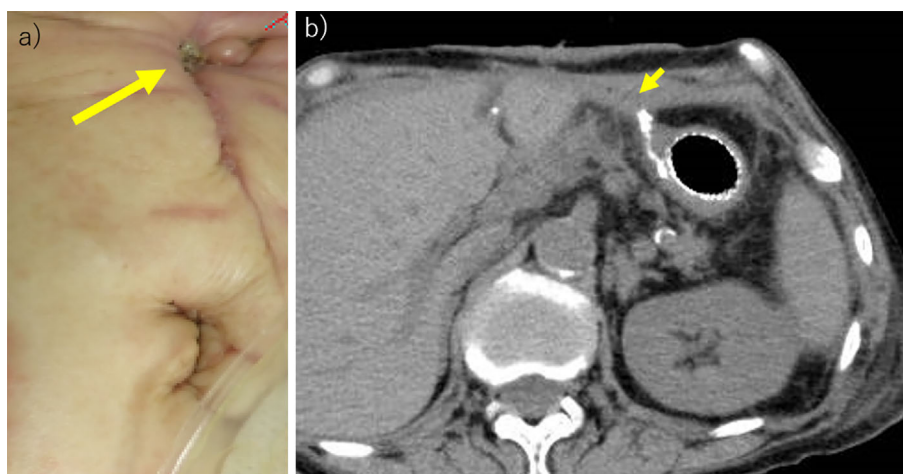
a) One month after the stent placement, the cutaneous opening of the fistula had closed. The yellow arrow indicates the scar at the site of the cutaneous opening. b) Computed tomography image showing the remaining jejunocutaneous fistula (yellow arrow). Compared to Fig. 1b, the presence of subcutaneous air had disappeared.
